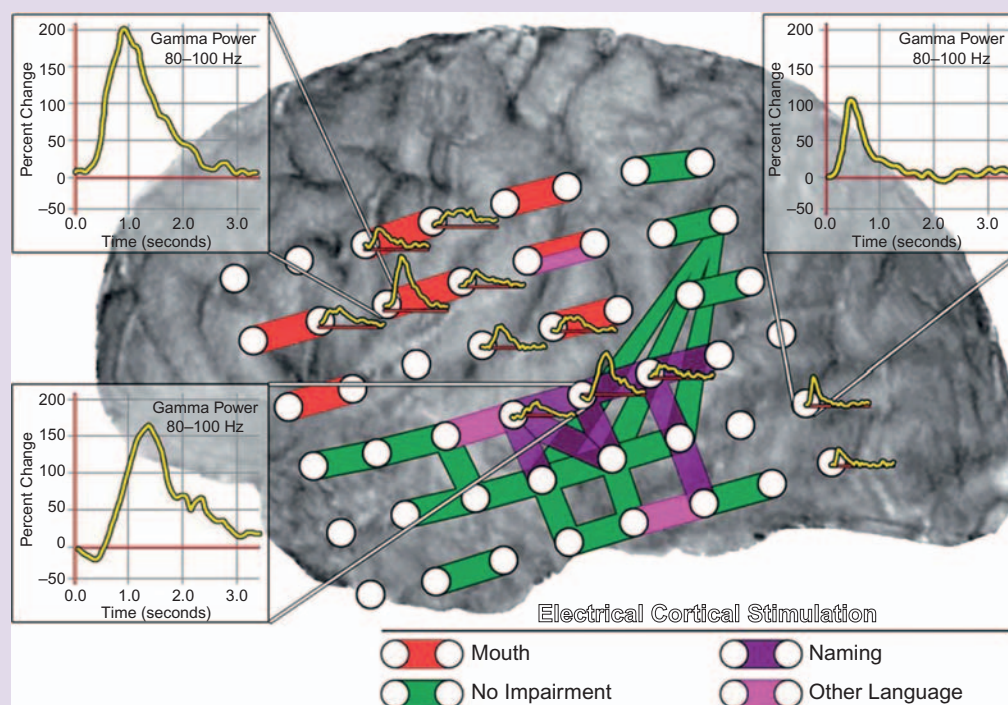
The results of an ECoG study of an epileptic patient, shown over an MRI of the lateral brain. The three inset graphs show a fast increase in high gamma activity (80–100 Hz) immediately after a picture with an object to be named is presented. The patient is asked to name the object, and the electrical activity is averaged over all presentations. The colored strips show which electrode pairs were used for cortical stimulation, which typically interferes with the functioning of the underlying cortical area. The red and purple strips mark places where electrical stimulation interfered with picture naming, mouth movements, and other language responses. The green strips indicate electrode pairs for which electrical stimulation caused no task interference. *Source:* Crone, Sinai, & Korzeniewska, 2006.
